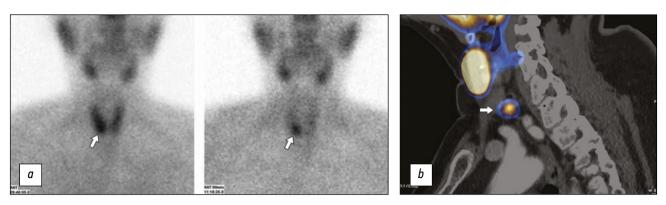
^{99m}Tc-MIBI radionuclide examinations (technetril): *a*, dual-phase planar scintigraphy (early and delayed scans). A parathyroid mass is visualized in the right lobe projection (arrows) with preserved and increased accumulation of radiopharmaceuticals on the delayed scan; *b*, ^{99m}Tc-MIBI SPECT/CT. A periothyroid mass is visualized behind and downward from the lower pole of the left lobe (arrow), which accumulates radiopharmaceuticals.
